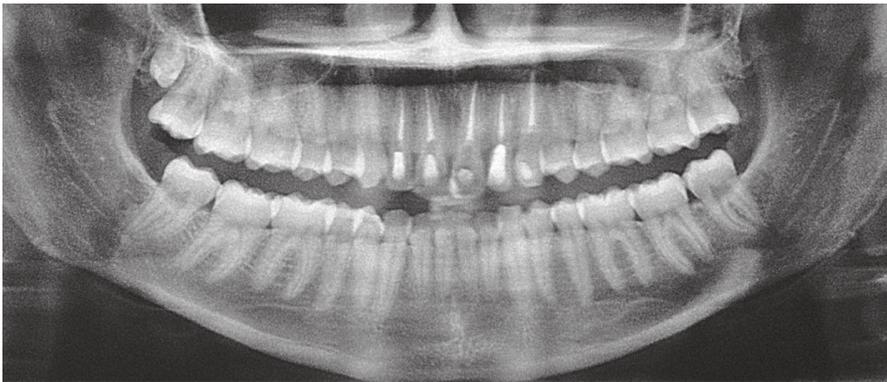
Panoramic radiograph after a two-year follow-up. Note bone formation on the apex of endodontically treated teeth.
